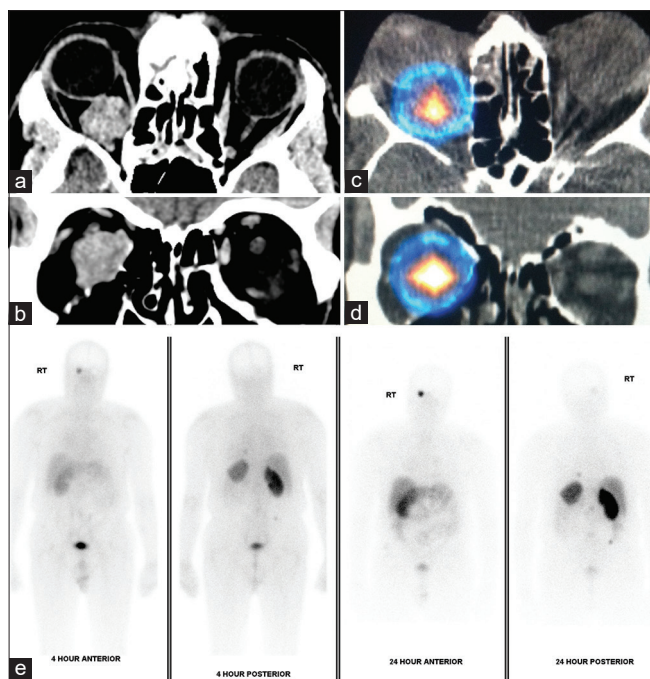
Image panel – Contrast-enhanced computed tomography identifies a mass in the right retrobulbar space on axial and coronal slices (left upper images, a and b). Single photon emission computed tomography/computed tomography and planar indium-111 octreotide demonstrates a solitary metastatic deposit (right upper and bottom row images, c-e)
